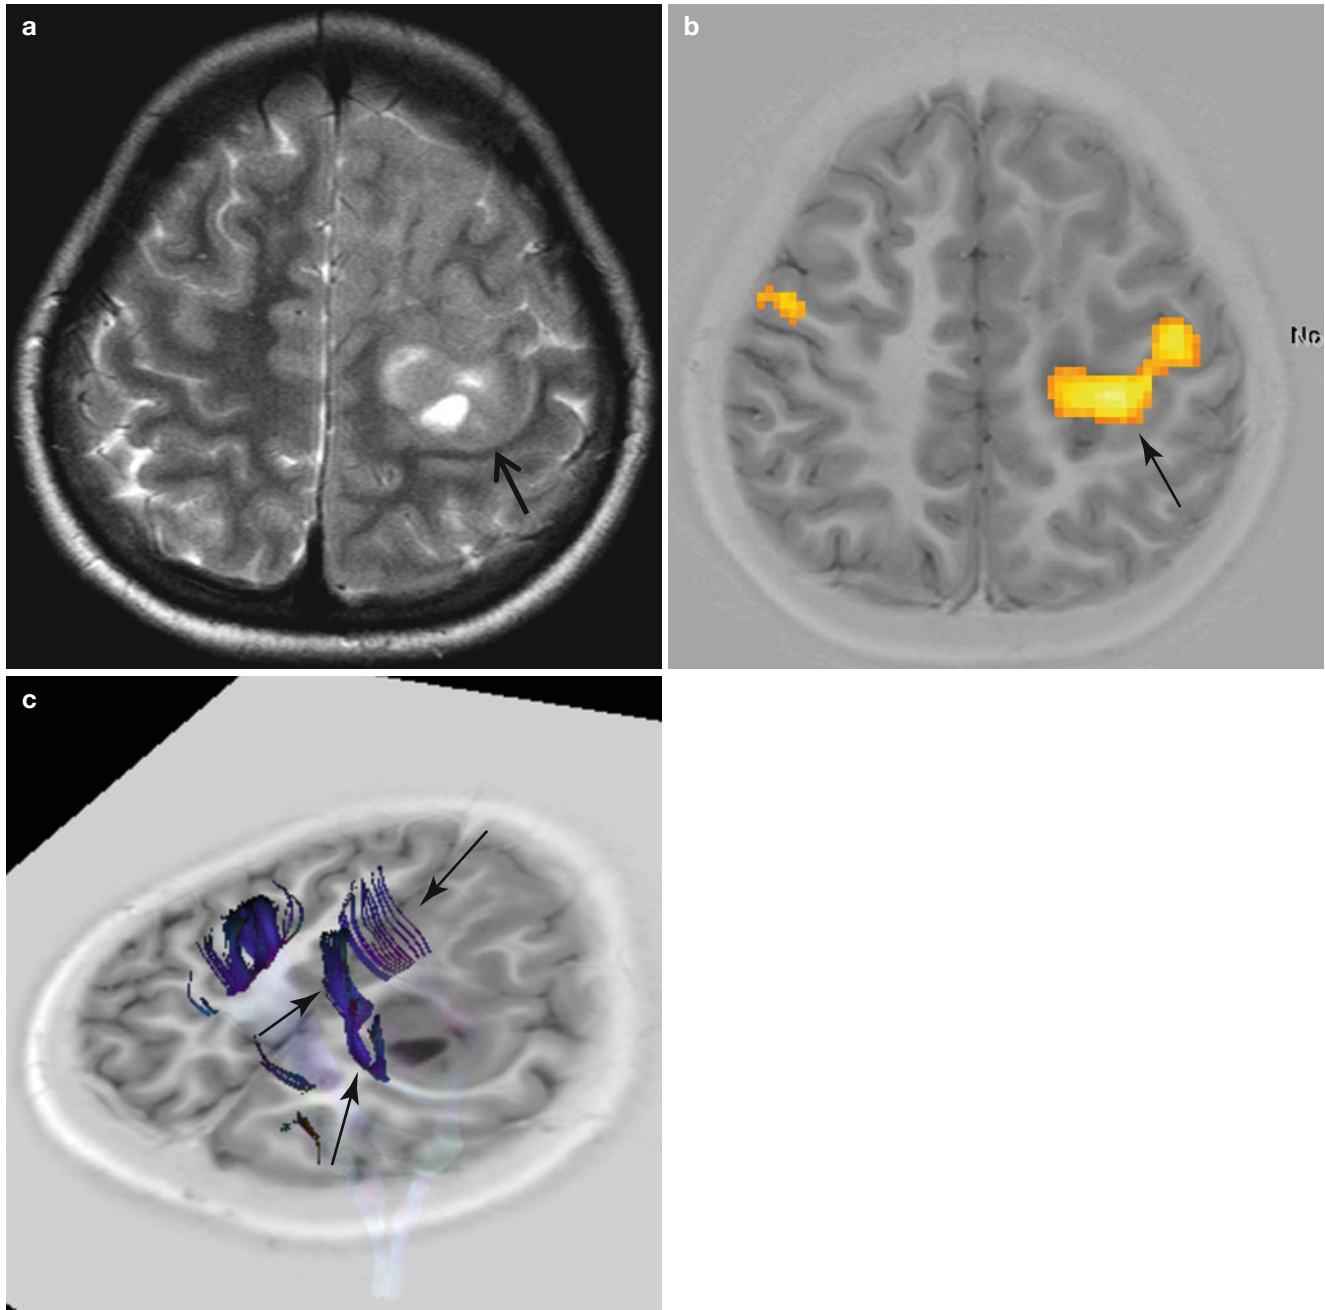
Functional MRI and tractogram of malignant glioneuronal tumor in a 15-year-old girl. (a) T2-weighted image shows ill-defined iso-signal intensity mass (*arrow*) with mild edema in the left frontal lobe raising suspicion of motor and sensory cortex involvement.
